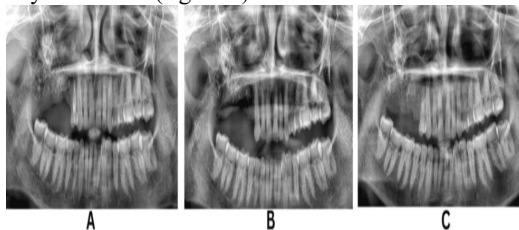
Radiographic images
